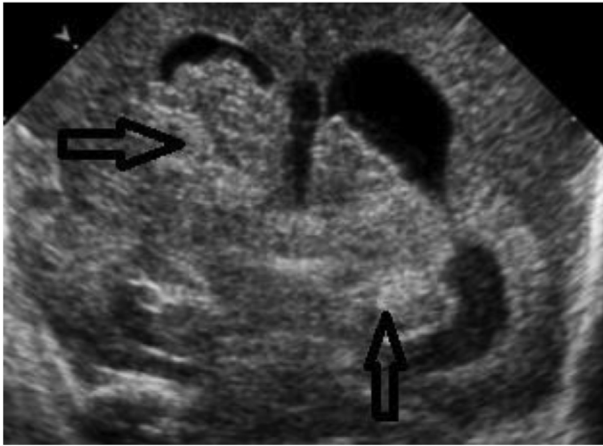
Coronal and Sagittal ultrasound scan of neonatal brain shows hyperechoic blood density at the caudothalamic groove (open black arrows) denoting germinal matrix grade I intracranial hemorrhage.
